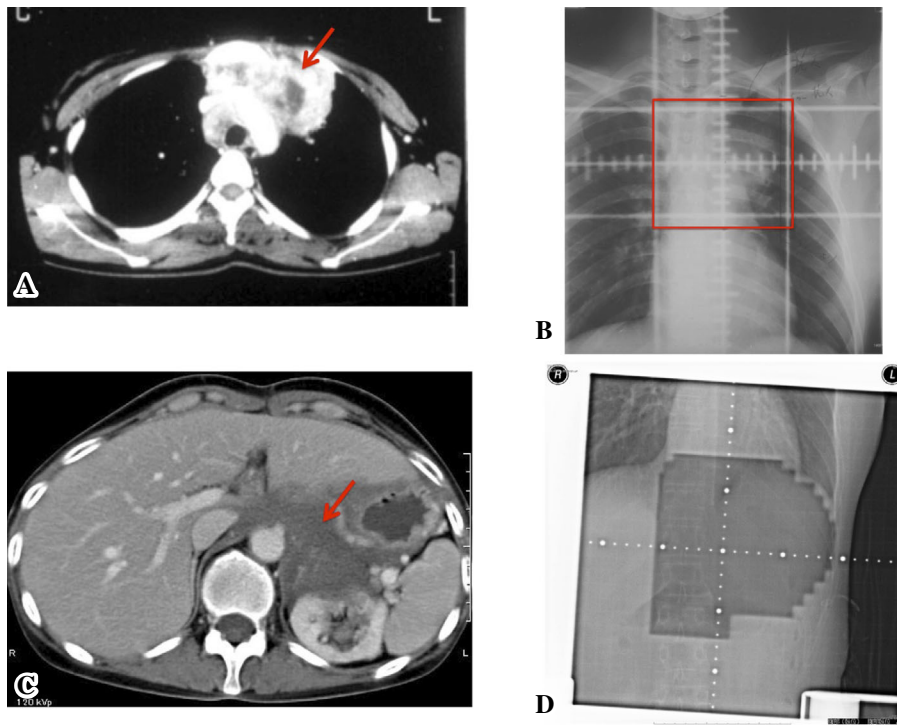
Chest contrast-enhanced CT finding of primary Hodgkin's lymphoma (A: arrow). Chest X-ray and irradiated lesion of the primary tumor (B: red line). Abdominal contrast-enhanced CT finding of tumor recurrence that developed two years after the first radiation therapy session for the primary tumor (C: arrow). X-ray of the irradiated lesion for tumor recurrence (D). CT: computed tomography
